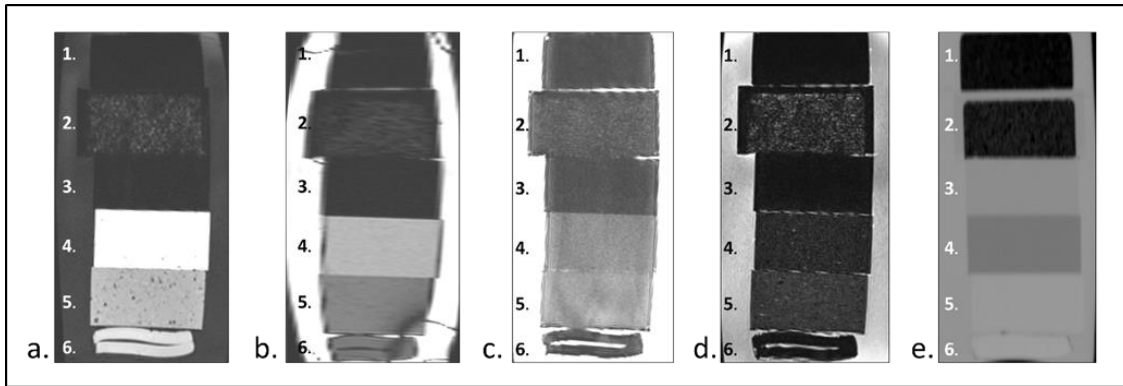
From top to bottom the materials shown are: 1.) compressed cork, 2.) in-house petroleum/styrofoam mixture (8.3% weight composed of mini Styrofoam balls and 91.7% weight composed of Sonneborn's Petroleum jelly), 3.) polystyrene, 4.) Clear Ballistic Gel #20, 5.) M-F Manufacturing 100% liquid PVC plastic, and 6.) Superflab. Four different MR sequences (a-d) and a CT scan (e) were performed on these materials to visually determine their contrast between water and IROC-Houston's conventional materials. The MR sequences shown in this figure were a (a.) T1-weighted, (b.), TRUFI, (c.) T2-weighted, and (d.) fluid-attenuated T2-weighted scans. The HU measured from the CT image for compressed cork, in-house petroleum/styrofoam mixture, polystyrene, Clear Ballistic Gel #20, Liquid plastic, and Superflab were, respectively, -800, -685, -33, -160, 20 and 51.
